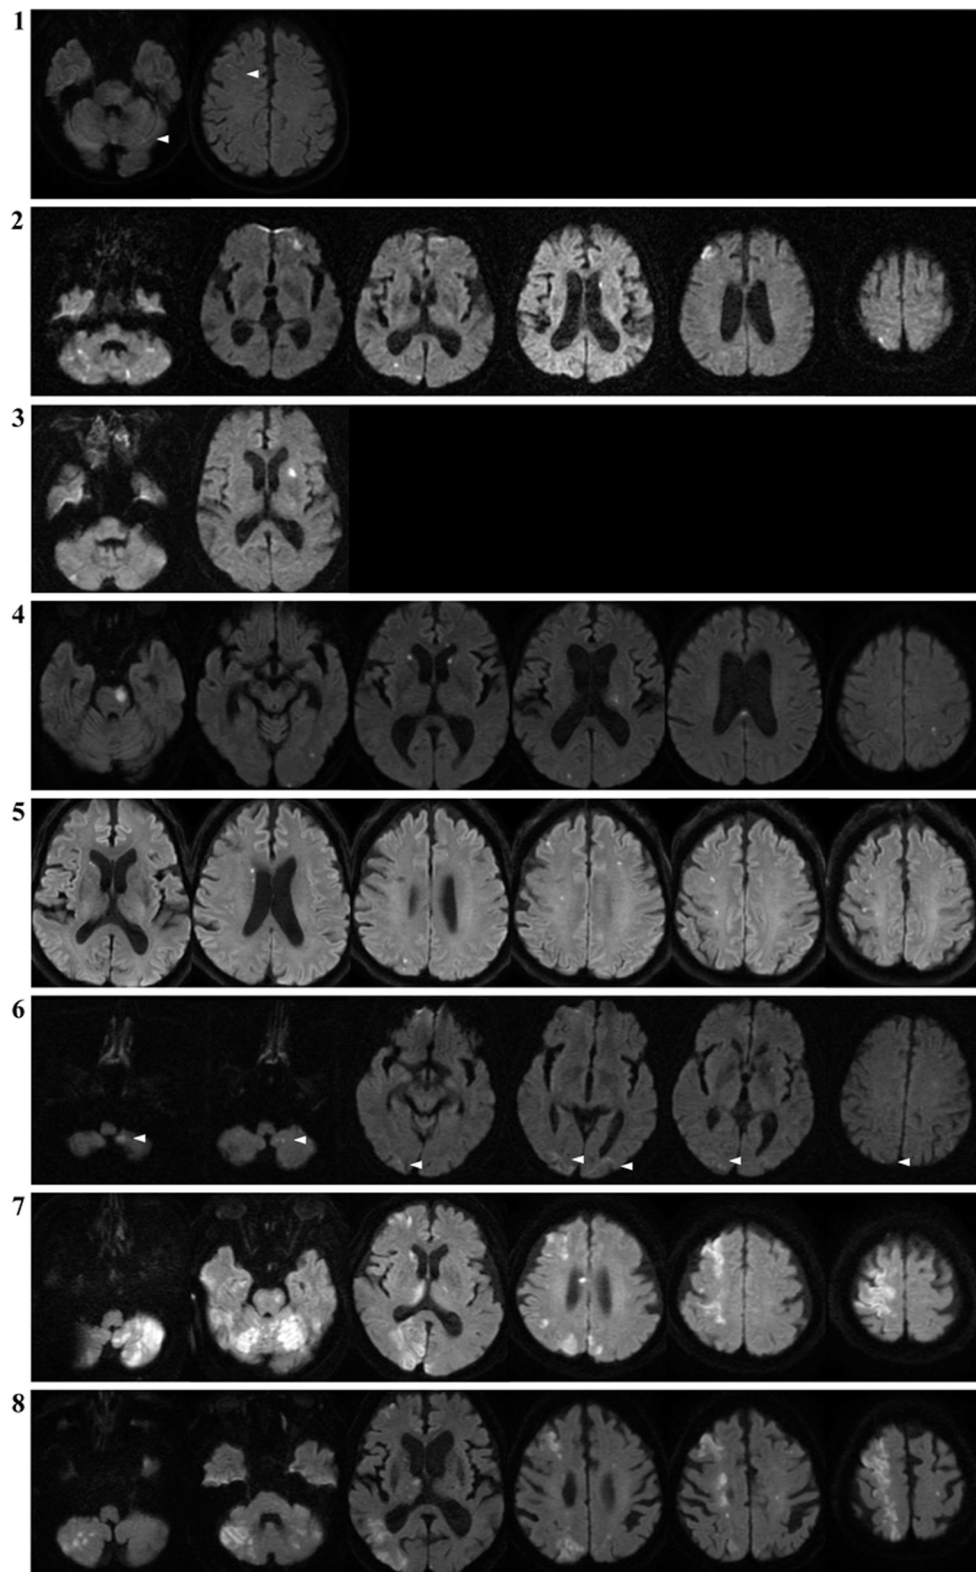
Representative axial diffusion-weighted magnetic resonance images from patients with CCE-CI showing infarcts in multiple vascular territories: Five patients (Nos. 2, 4, 6, 7, and 8 from [Table 1](#)) developed multiple infarcts in three territories (arrowhead), while three others (Nos. 1, 3, and 5 from [Table 1](#)) developed infarcts in two territories.
